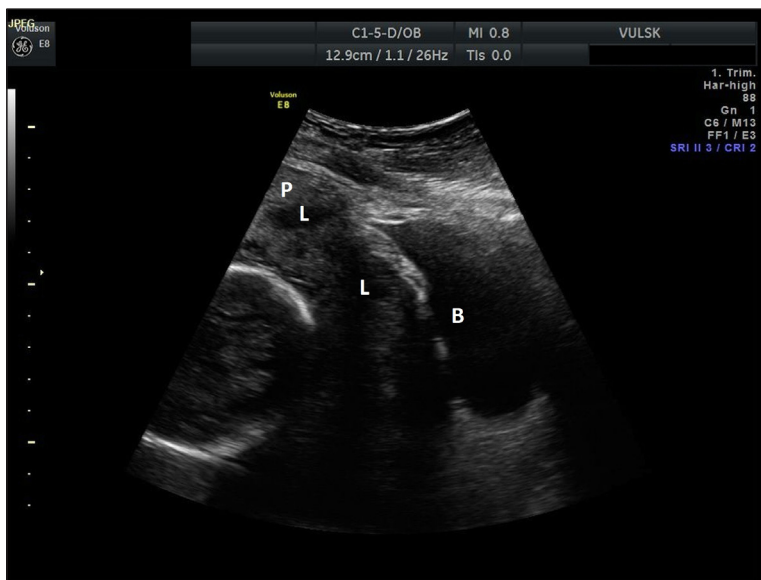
An ultrasound image in greyscale mode. Abdominal probe. Placenta (P) on the anterior wall covers the uterine scar area and overlies the endocervical os. The boundary between myometrium and the placenta is not clear, the deformation of the uterine wall near the bladder (B) is observed. Lacunar spaces (L) of various size and irregular are present in the placenta
